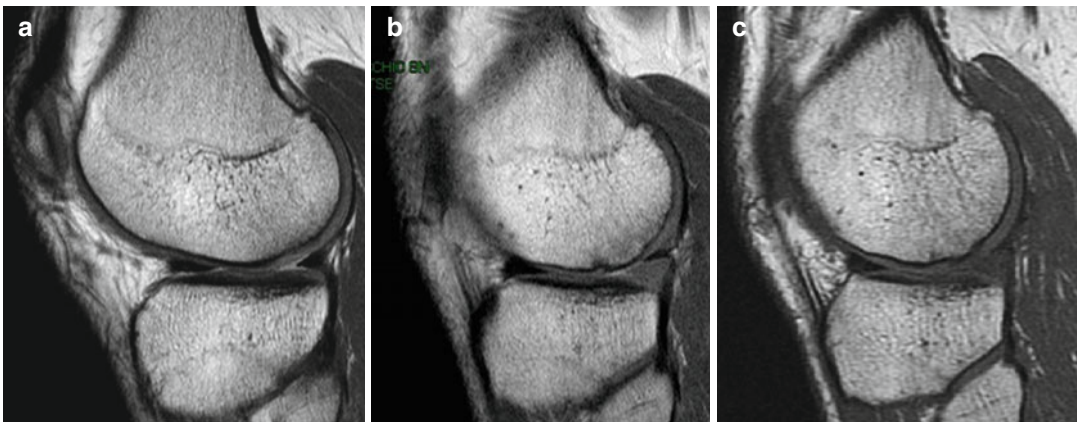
Sagittal MRI slice before medial Actifit® implant (a), after 6 months (b), and after 12 months (c). Posterior horn defect filling and progressive enhancement of scaffold signal is present
